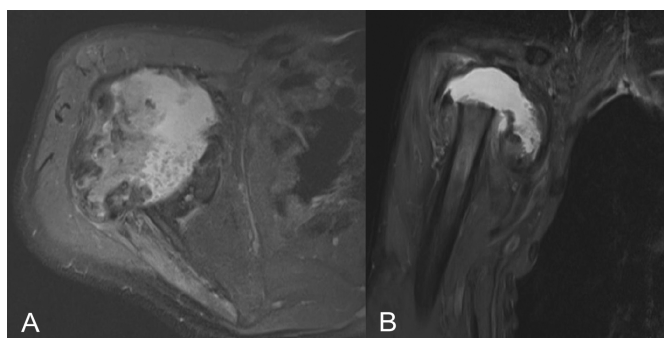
Axial and coronal MR imaging of the shoulder revealed a large amount of effusion, synovial hypertrophy, destruction of the humeral head, and a large irregular leaf-tissue masses formation.
